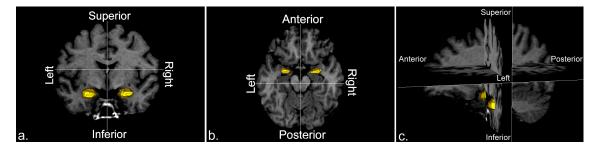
a. Coronal, b. axial, and c. orthogonal cross-sections of a subject's MRI image are shown with 3D renderings of their segmented amygdalae. Visualization performed with in-house software designed with the Insight Toolkit (http://www.itk.org), Fast Light Toolkit (http://www.fltk.org), and Visualization Toolkit (http://www.vtk.org).
